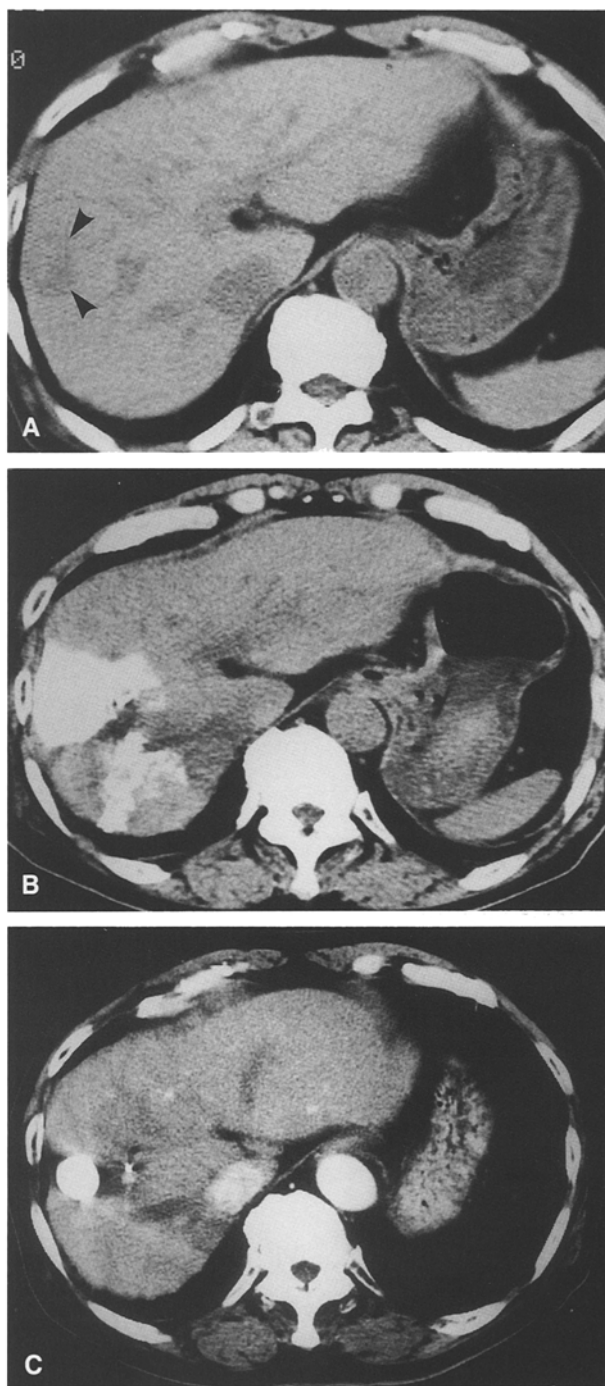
A 72-year-old man with nodular hepatoma treated by embolization of the branch of a hepatic artery (S5) using iodized oil/cisplatin without Gelfoam particles. A Precontrast CT shows a slightly hypodense mass in the right lobe (*arrowheads*). A branch of the right hepatic artery was embolized using iodized oil/cisplatin (segmental TAE). B Precontrast CT obtained 1 week after TAE shows dense accumulation of iodized oil in the liver parenchyma of the tumor-bearing segment, as well as in the tumor. Iodized oil is also seen in the posterior segment (S6). C Contrast-enhanced CT obtained 20 weeks after TAE shows marked atrophy of the liver parenchyma surrounding the tumor, corresponding to the area of iodized oil accumulation.
